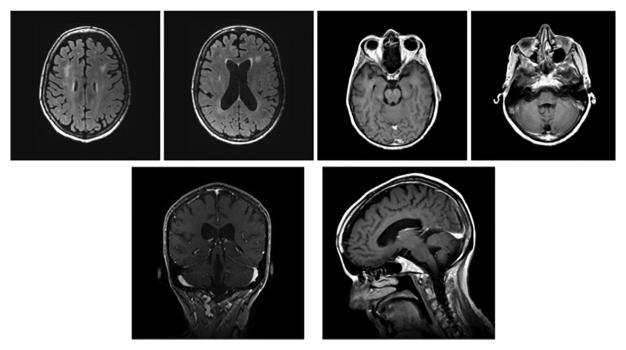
Pertinent T-2/FLAIR MRI images in axial, coronal and sagittal. Findings include: (Jemal et al., 2011) Stable pattern of cranial nerve enhancement keeping with patient's known leptomeningeal disease. (Johnson, 1993) More confluent pattern of hyperintense signal within the bilateral corona radiata and centrum semiovale which may be related to chemotherapy treatments. (Toyoshima et al., 2017) Stable to slight interval increase in parenchymal volume loss.
